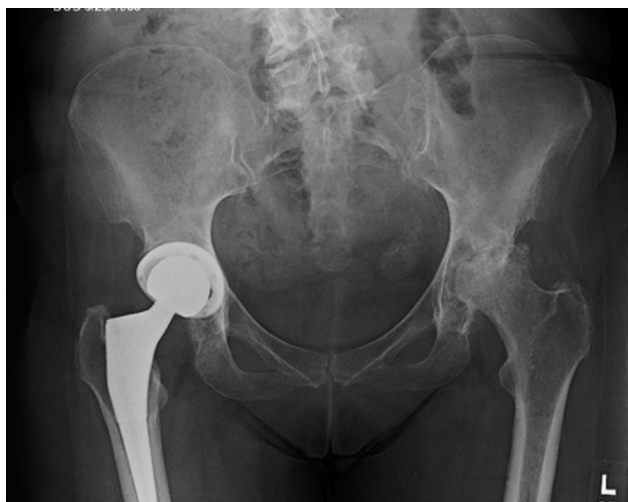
Preoperative anteroposterior pelvis radiograph of case 3 demonstrates severe osteoarthritis with extensive cystic erosions of the acetabulum, and loss of the lateral rim consistent with Paprosky 2B defect.
